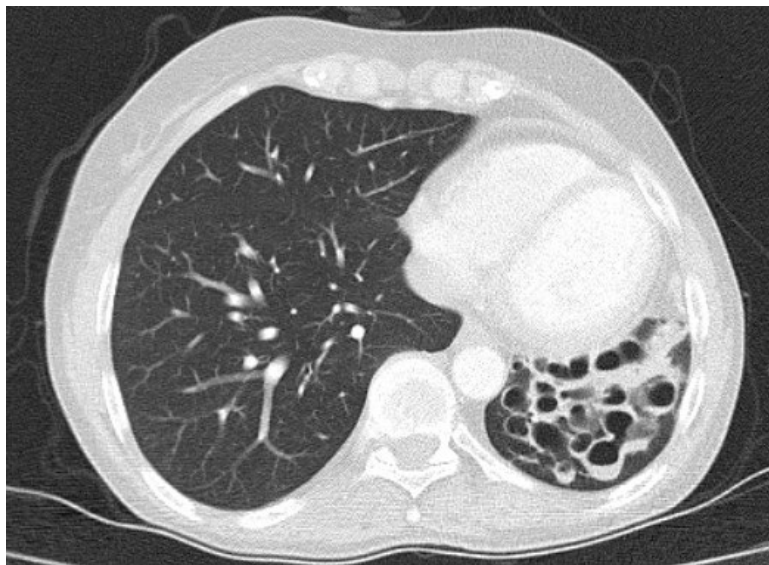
Bronchiectasis in the lower lobe of the left lung on thorax CT
